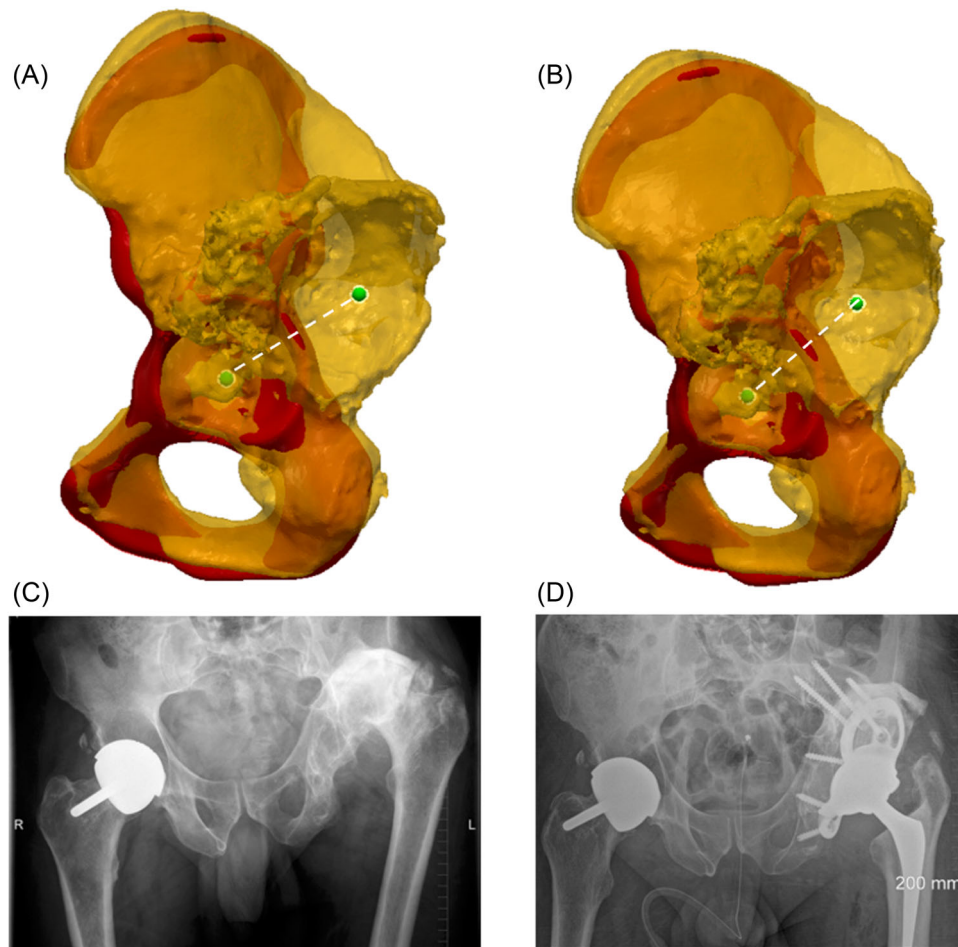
(A) Anterior–posterior and (B) lateral views of the difference in center of rotation (CoR) between the Statistical Shape Model and the diseased hip—significant change in Z is observed. (C) Anteroposterior plain radiographs taken preoperatively and (D) postoperatively showing restoration of the CoR. [Color figure can be viewed at wileyonlinelibrary.com]
